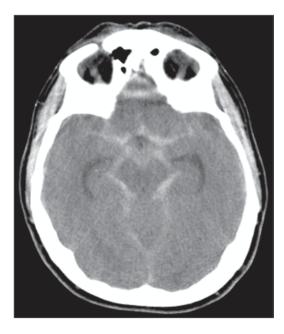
Computed tomography (CT) scan of subarachnoid hemorrhage. (Courtesy of Blaine Hart, MD)
